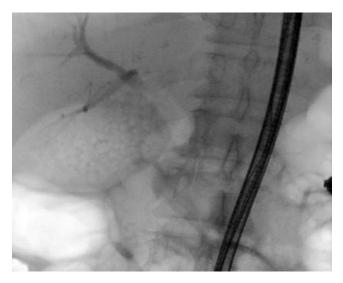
Final post-ERCP x-ray. Source: Authors' archive.
